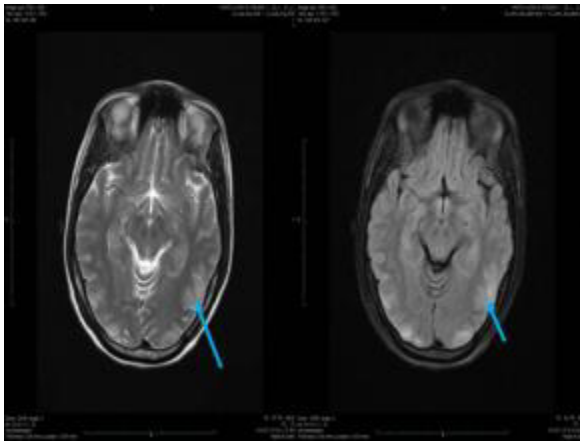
Axial FLAIR and T2 images near symmetrical areas of abnormal intensity in bilateral parieto-occipital region
